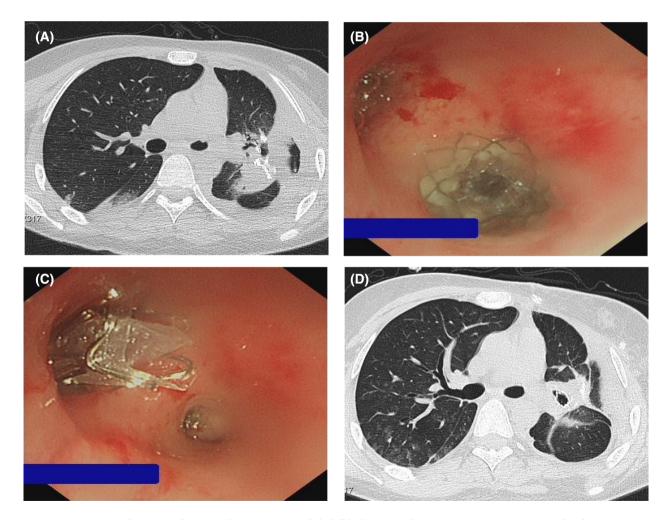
Case 1: (A) The computed tomography (CT) scan revealed a left hydropneumothorax. (B) A version 4.0 EBV was placed in LB4 in reverse, with the edge of the EBV covering LB5. The dye entered the intrinsic segment bronchus of the left upper lung after retrograde MB instillation. (C) The EBVs inside the bronchi were removed and replaced in a forward direction into LB4 and the left intrinsic segment bronchus. (D) During the follow-up period of 6 months, a CT scan showed neither pneumothorax nor empyema.
